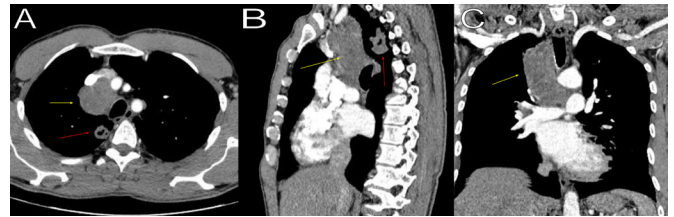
Chest CT scan with intravenous contrast (A) axial, (B) sagittal, (C) coronal images show a superomedial mediastinal heterogeneously enhancing mass (yellow arrow), measuring 4.3 cm anteroposterior × 4.5 cm transverse × 8.4 cm craniocaudal. The mass is adherent to the right lung without invading it. A smaller pleural-based pulmonary lesion (red arrow) with an internal cavity is identified in the right posteromedial lung apex paravertebral region, measuring 3.7 cm × 2.2 cm × 1.9 cm.
